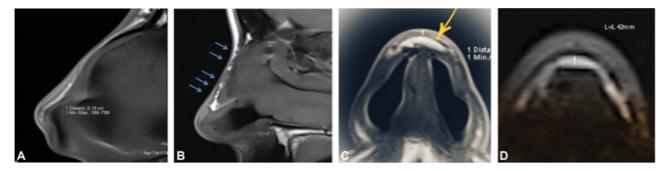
Sagittal T1-weighed magnetic resonance imaging (MRI) scan of patient without nasal intervention and normal anatomy (A). Postoperative, sagittal high-resolution MRI of patient 12 months after rhinoplasty. In T1-weighed imaging fat islands can be identified in the nasal dorsum with a maximum in the supratip and radix area (arrows) (B). In axial view the transplanted fat layer can also be distinguished as a max. 1.42 mm fat-isodense area in the deep subcutaneous location above the cartilaginous framework.
